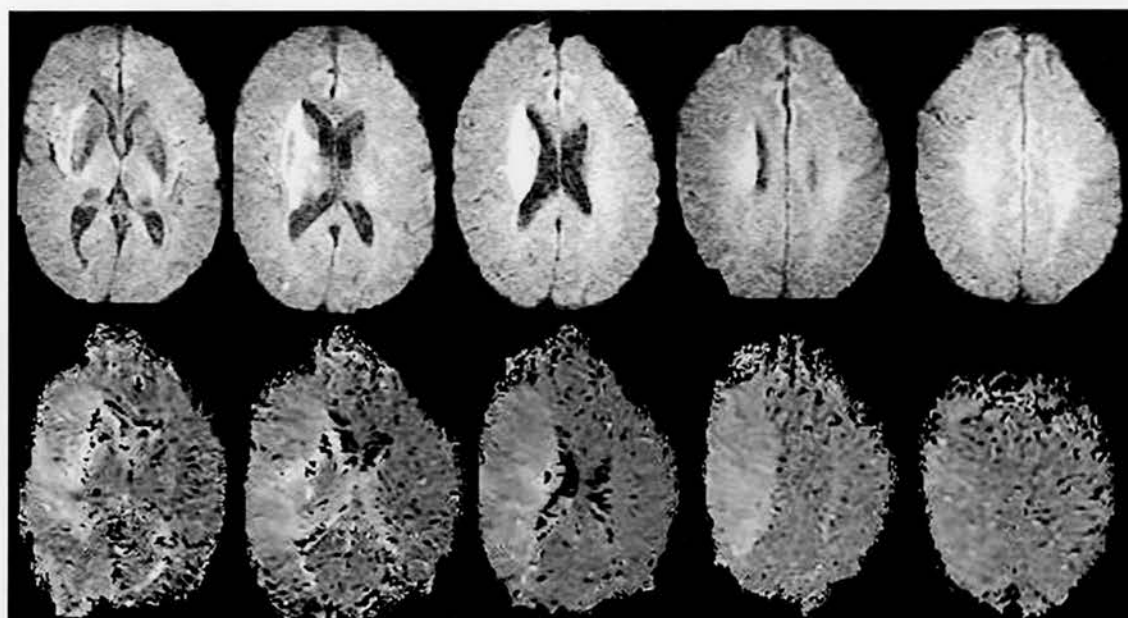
Top row shows DWI changes in the right MCA territory. Second row show the rMTT map for this case, with PWI>DWI lesion (mismatch). This case was rated by the six experienced observers as having a mismatch ranging from 30 % to 100 %. The error range of the measurement across all cases is  $\pm 21.6\%$ .
